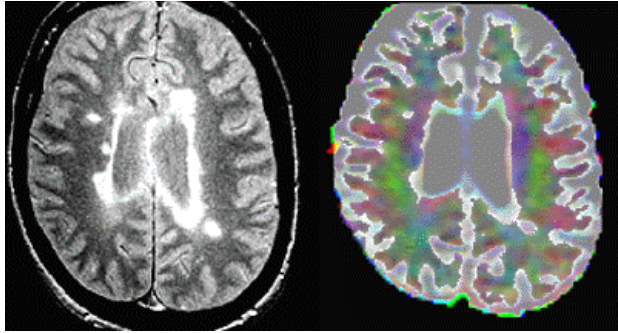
Comparison of MR image and MR diffusion tensor image of the brain. (Permission from Dr. Jianhui Zhong)
